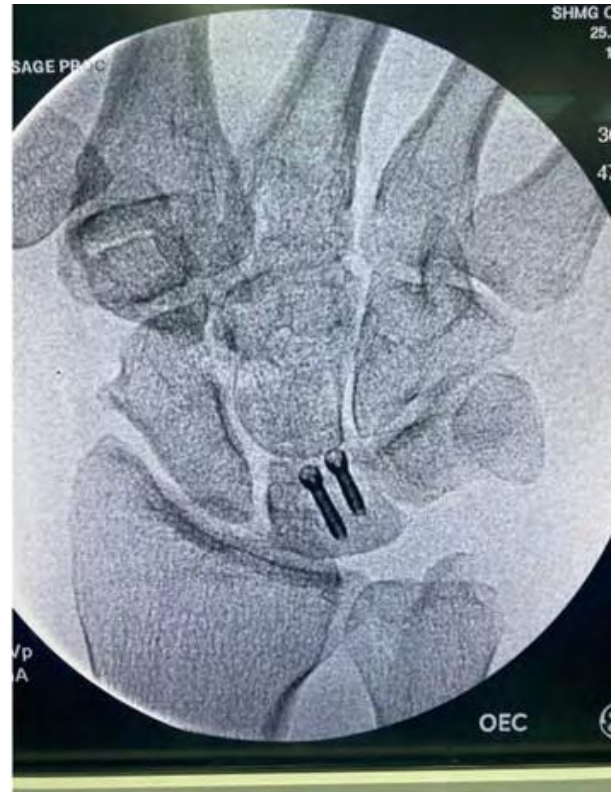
Anteroposterior radiographs of the right wrist taken after the fixation of the lunate bone showing two headless screws over the lunate.
